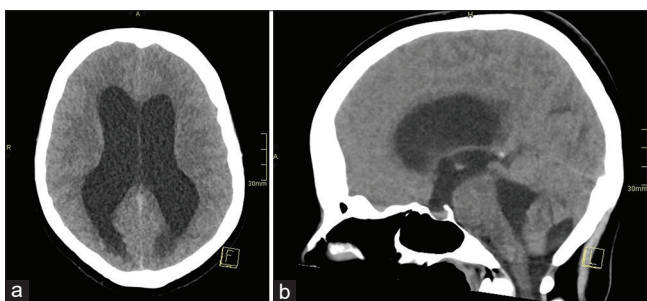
(a) Axial and (b) sagittal computed tomography (CT) scans reveal the presence of ventriculomegaly and hydrocephalus.
